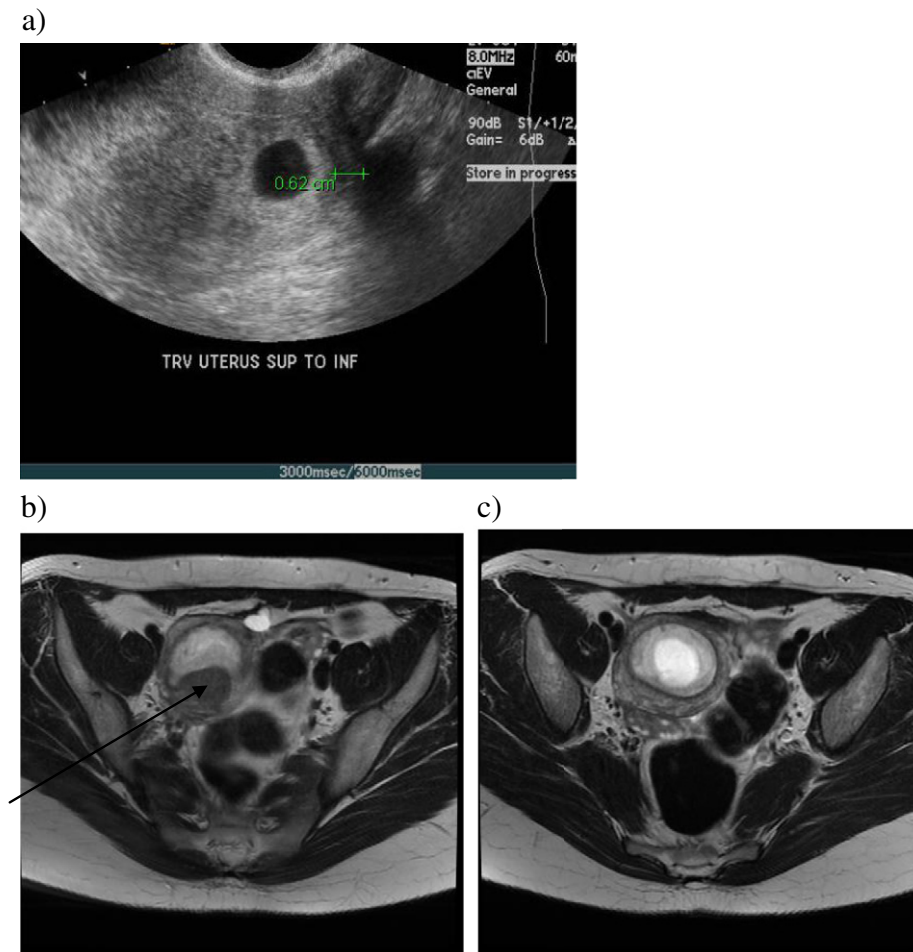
Uterine leiomyomas may cause a normal pregnancy to appear eccentric in location and therefore confused with an interstitial pregnancy. (a) 2D transvaginal grayscale US image of an early first-trimester pregnancy demonstrates a gestational sac (with surrounding echogenic halo thought to be due to decidual reaction) eccentrically located in the left superior lateral aspect of the uterus; although the surrounding myometrial layer is >5 mm, in the impression, the interpreting radiologist raised the possibility of a “cornual pregnancy.” (b) MRI obtained for further characterization demonstrates on this axial T2-weighted images (W 2744, L 1372) a right-sided myoma (arrow), probably accounting for the leftward appearance of the gestational sac on US, but a normal, centrally located IUP in a uterus of normal configuration (c); this pregnancy went to term, yielding a normal male infant.
